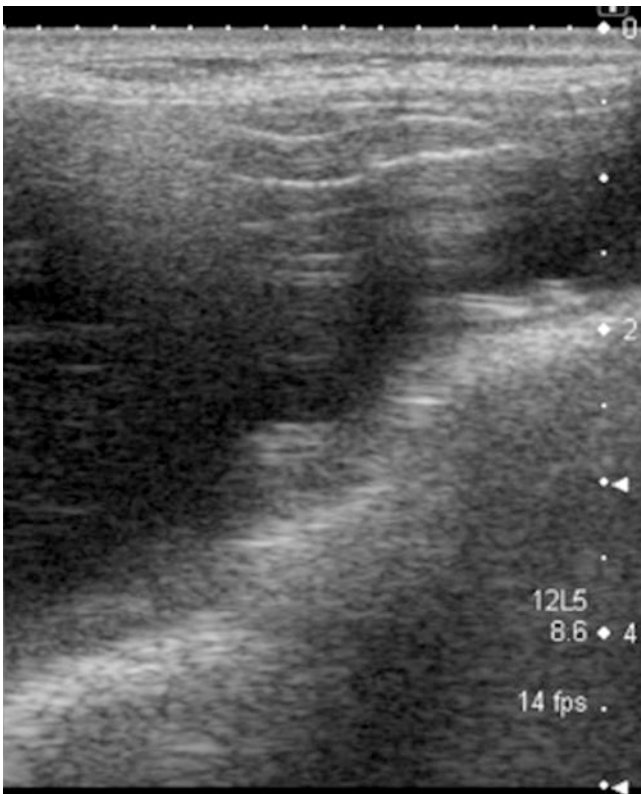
Ultrasound showing an intracapsular rupture: stepladder sign. This image appeared in the *European Aesthetic Plastic Surgery Journal* (number 12). Reproduced with permission from the Asociación Española de Cirugía Estética Plástica
